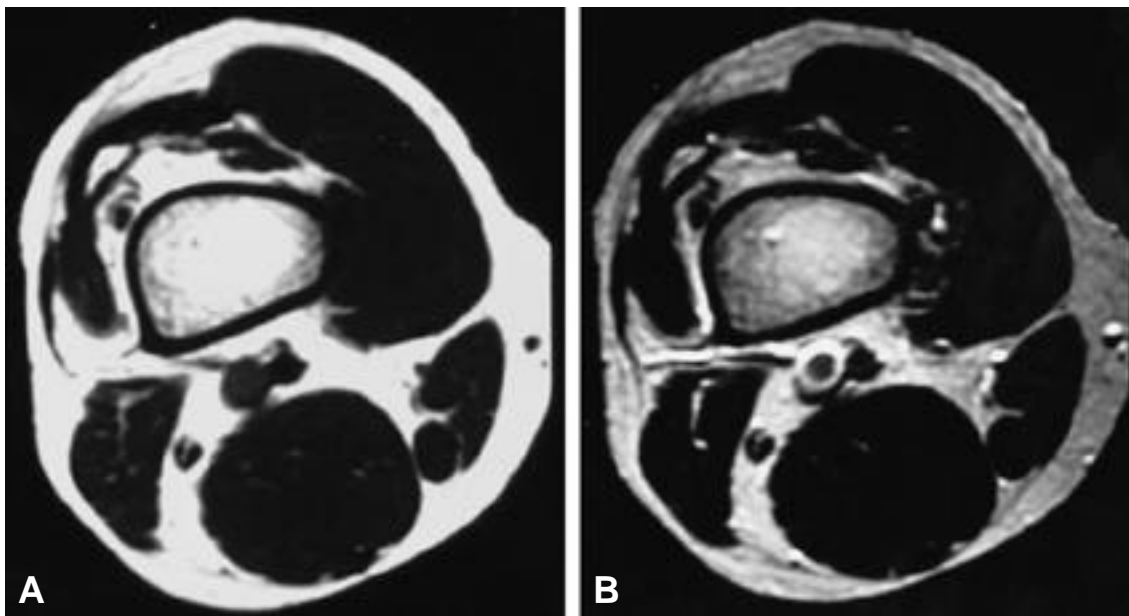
Mass with low signal intensity in T1 weighted MR image (A) and intermediate to high signal intensity in T2 weighted MR image (B).
